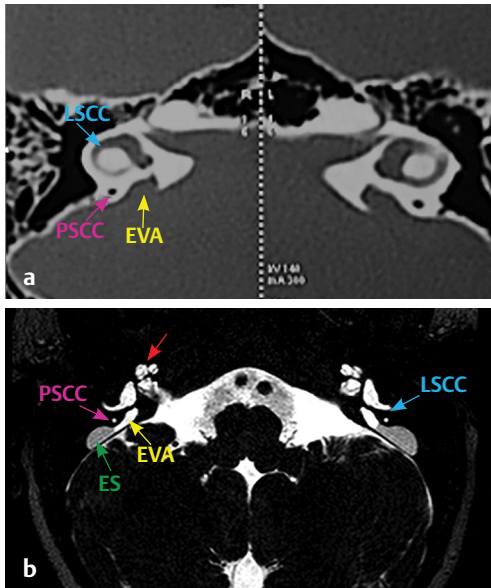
(a) HRCT temporal bone, bone window and (b) MRI CISS sequence, axial sections show SMS CVM type 1 with normal cochlea and EVA (yellow arrow), PSSC (pink arrow), LSCC (blue arrow), and endolymphatic sac (ES, green arrow).
